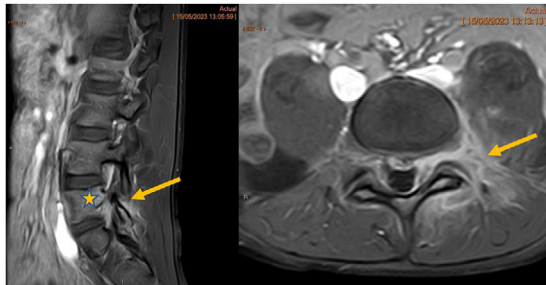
Magnetic resonance image (post-contrast T1-weighted fat-saturated sagittal and axial views). Marked enhancement of the bone marrow of the pedicle and left articular processes of L5 (star) and the periarticular soft tissues (arrows), with an inflammatory appearance, probably secondary to trauma.
